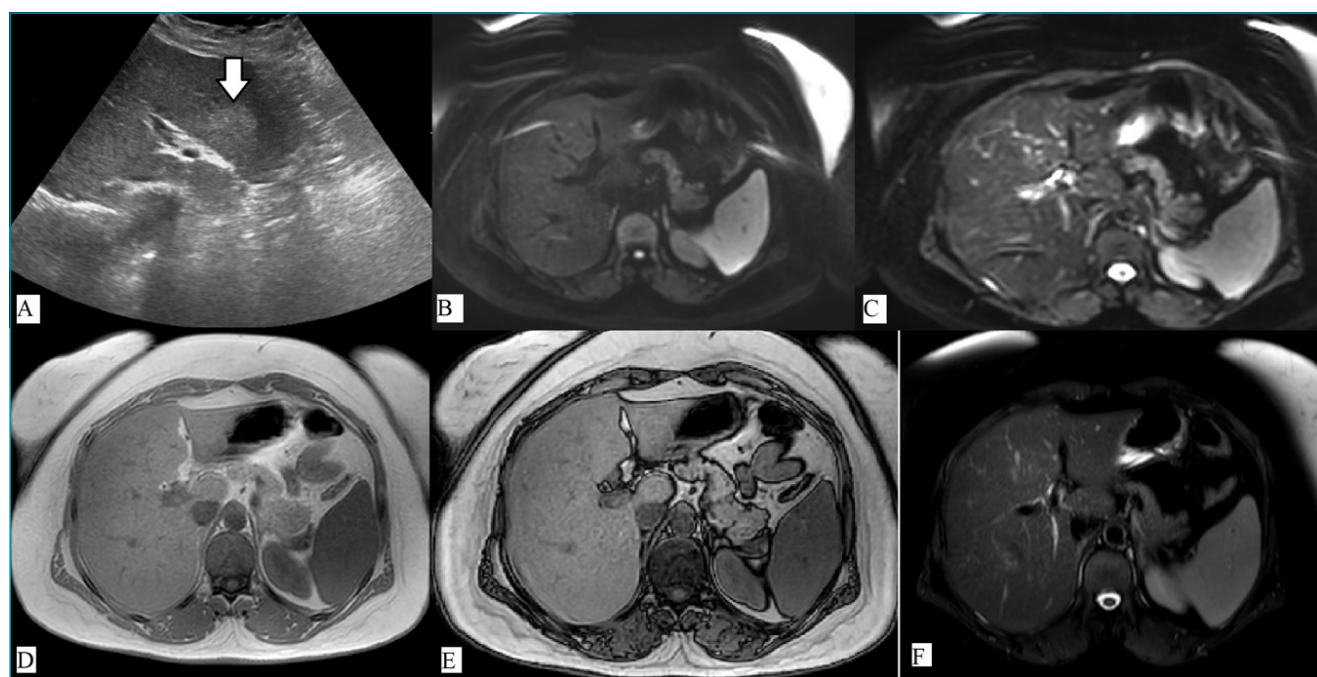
(A) Ultrasonography clearly demonstrates a hyperechoic area in the left lobe of the liver. (B), (C), (D), (E), and (F) No lesion is detected on diffusion weighted imaging, dual echo, and T2-weighted images. Images of a 43-year-old woman.
